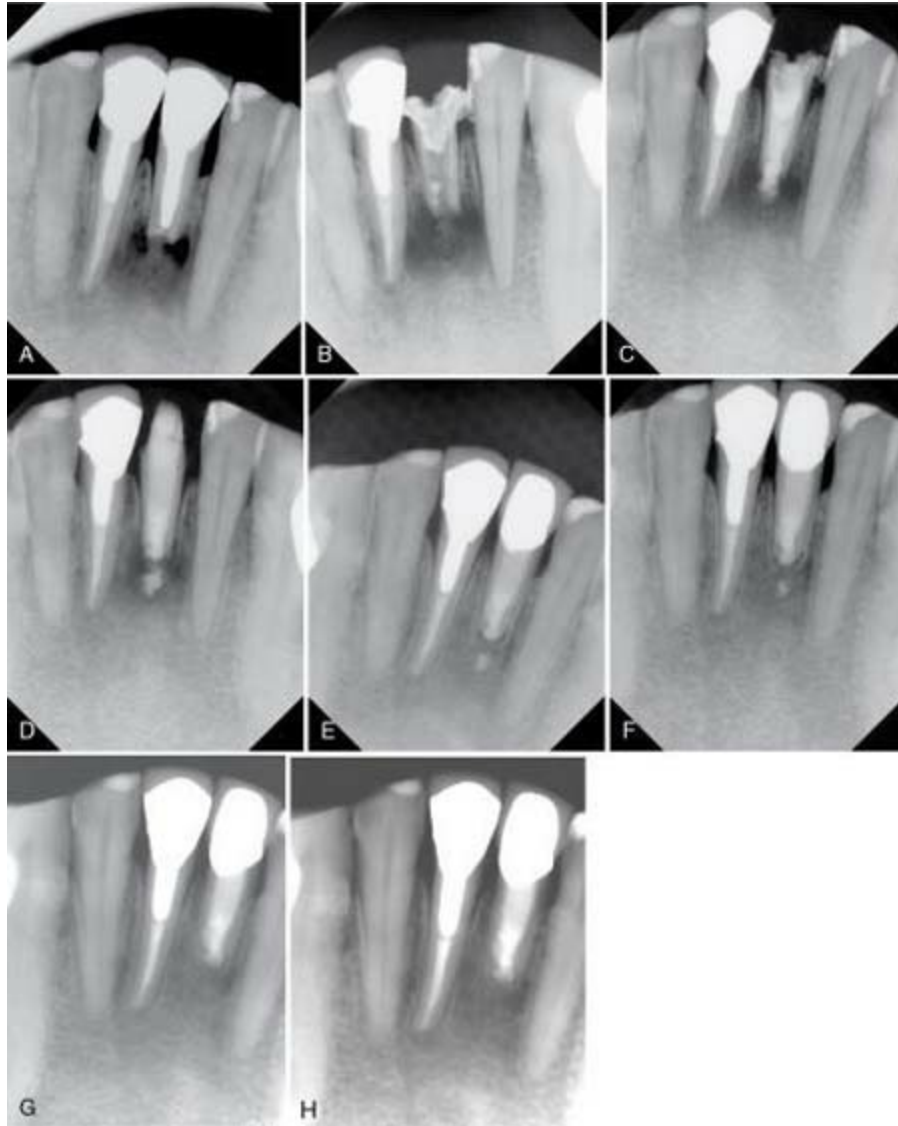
A, Preoperative radiograph showing a large periradicular lesion associated with the root of the mandibular left incisor. B, Intraoperative radiograph showing the cast post and the root filling in the canal was mechanically removed. Calcium hydroxide was placed as an intracanal dressing on the first appointment. C, Postoperative radiograph on the second appointment showing the canal was obturated with mineral trioxide aggregate (MTA), which resulted in overextension of the material into the periradicular tissues. D, Six-month postoperative radiograph showing the significantly reduced size of the lesion. E, One-year postoperative radiograph showing a nice periradicular healing with hard tissues formed on the radicular end of the MTA filling, resulting in a longer root aside from a residual of the MTA root filling extruded into the periradicular tissues. F, Three-year postoperative radiograph showing the tooth has maintained healthy periradicular tissues with the extruded MTA filling reduced in size. G, Twelve-year postoperative radiograph showing the tooth has
